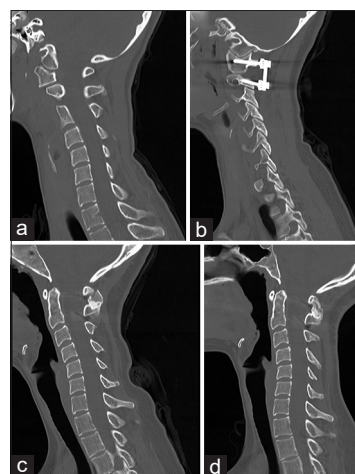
Case 3 imaging – Pseudoarthrosis (a) Preoperative sagittal rotational cervical CT turned to the left which demonstrates rotational subluxation in conjunction with axial views not shown. (b and c) Postoperative sagittal cervical CT 24 months after initial operation demonstrating pseudoarthrosis with bone graft incorporated into the C2 lamina but without bridging bone between C1 and the bone graft. (d) Postoperative sagittal cervical CT 47 months after the initial operation and 18 months after revision surgery demonstrating bony fusion and expected postoperative changes from a C1-2 posterior fusion. CT: Computed tomography
